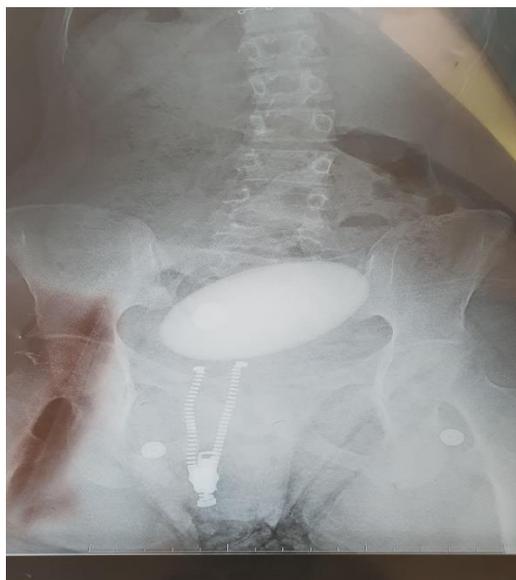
Abdominal radiograph (KUB) showing a giant oval Vesical calculus lying obliquely in the bladder region.
